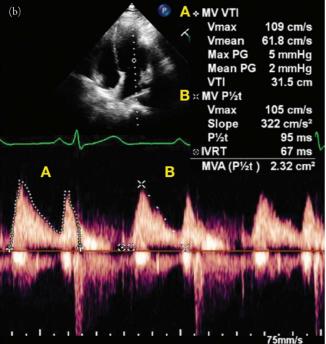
(a) Mitral valve area measurement using planimetry on a parasternal short axis window. (b) Doppler-based techniques to estimate the mitral valve area (MVA) in mitral stenosis. This is a continuous wave Doppler tracing of mitral inflow from an apical 4-chamber window. The first measurement (A) is a tracing of the E and A velocity time integrals (VTI), which generates a mean pressure gradient (MPG) between the LA and LV. An MPG >10 mmHg is considered severe. In (b), the pressure half time (PHT) is traced from the peak of the E wave to the base. A PHT is the time between the maximal mitral gradient to half this gradient. MVA is 220/PHT, so a PHT greater than 220 is indicative of severe mitral stenosis. Image courtesy of Robin Wachsner, MD, Division of Cardiology, Department of Medicine, Olive View–UCLA Medical Center, Los Angeles, CA.
